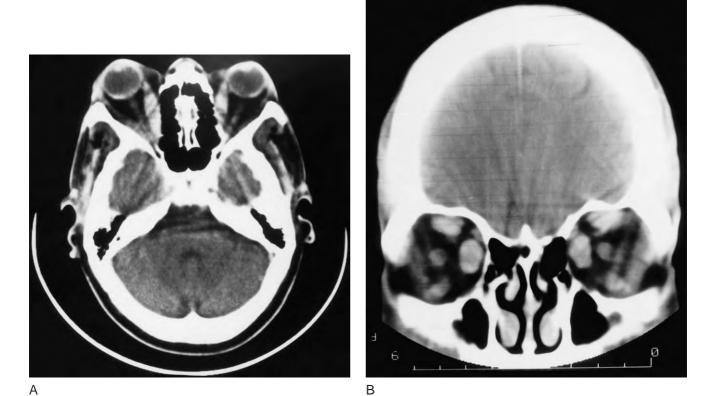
Computed tomography of the orbit in a patient with Graves' ophthalmopathy. (A) Proptosis and markedly enlarged extraocular muscles. (B) Coronal view showing extraocular muscle enlargement.
